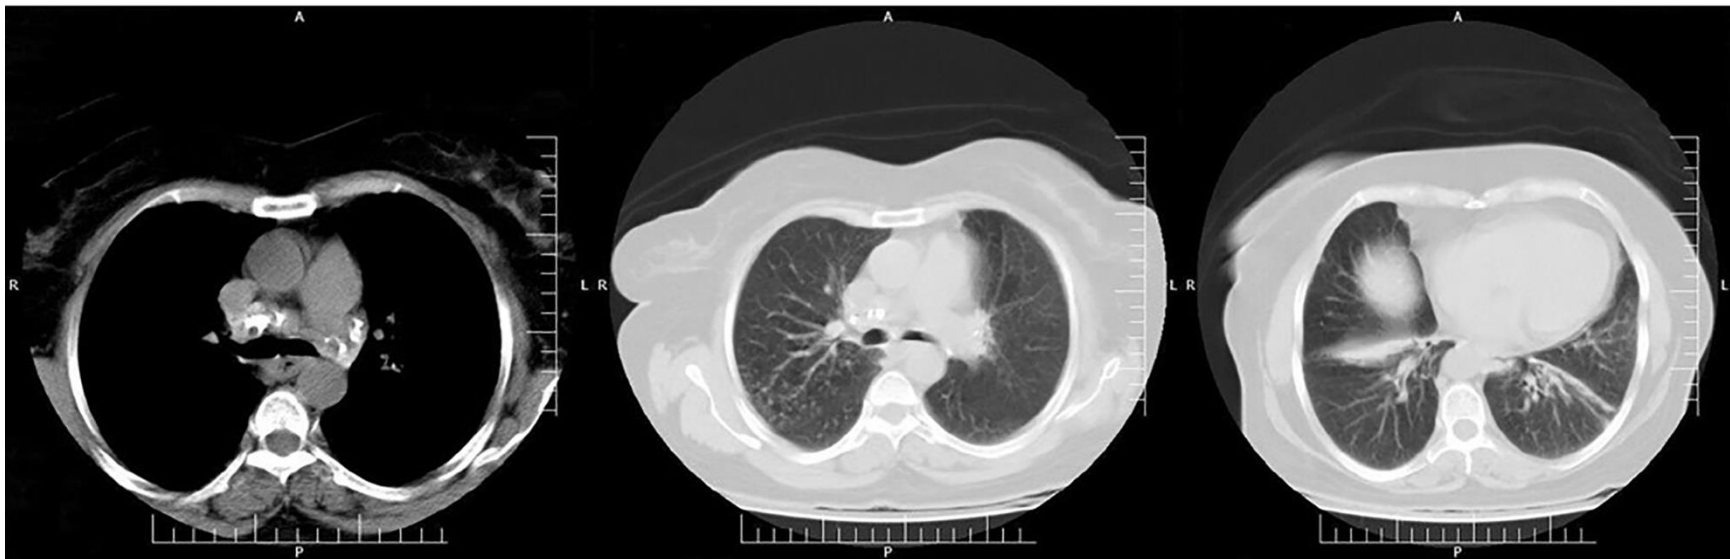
Chest CT scan image indicating calcified mediastinal lymph nodes, nodular opacities on both sides, a linear band in both lower lobes, partial wedge-shaped collapse in the right lower lobe, and fibrotic changes in the left lower lobe.
